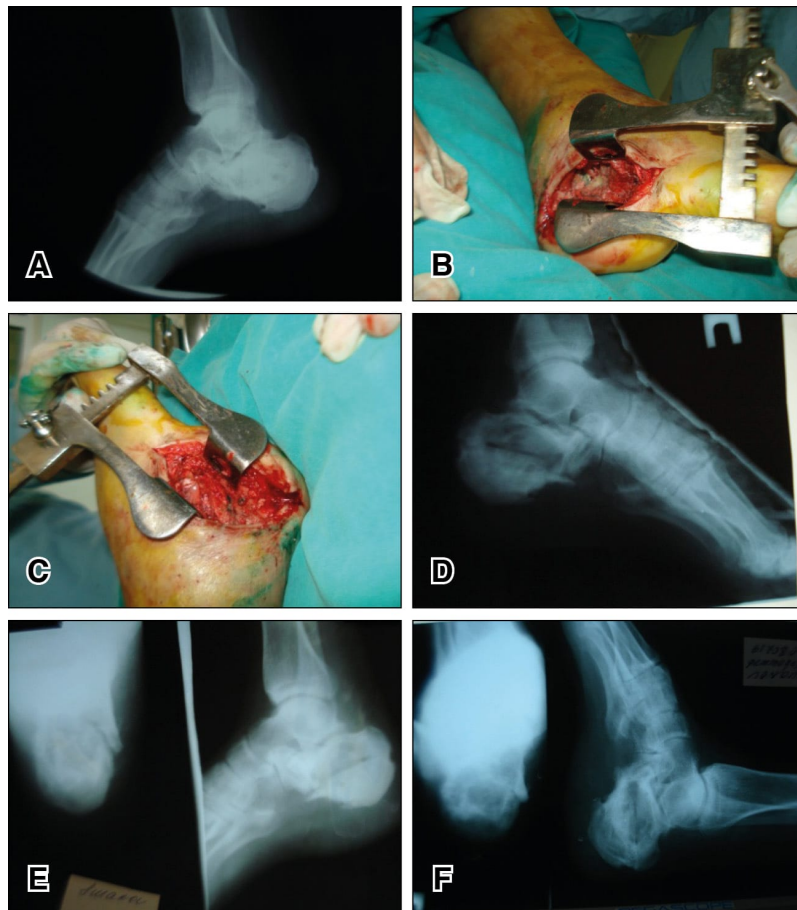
(A) X-ray of the right calcaneus before surgery. (B) intraoperative photographs after longitudinal osteotomy. (C) after intralésional resection. (D) x-ray after surgery. (E) x-ray after 2 months. (F) x-ray at 6 months-F.
